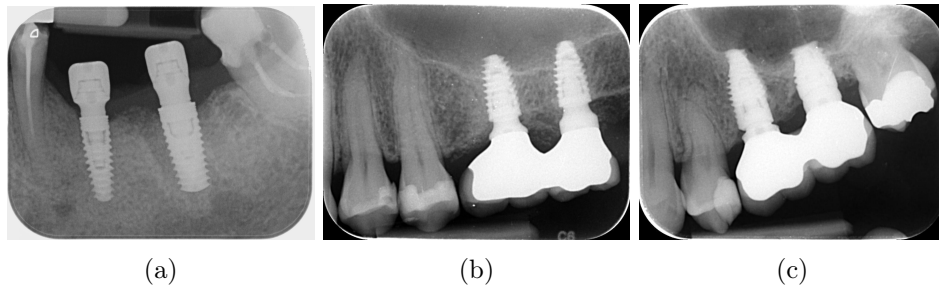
Examples of actual X-ray images within the context of the implants inserted into *human jaws*.
